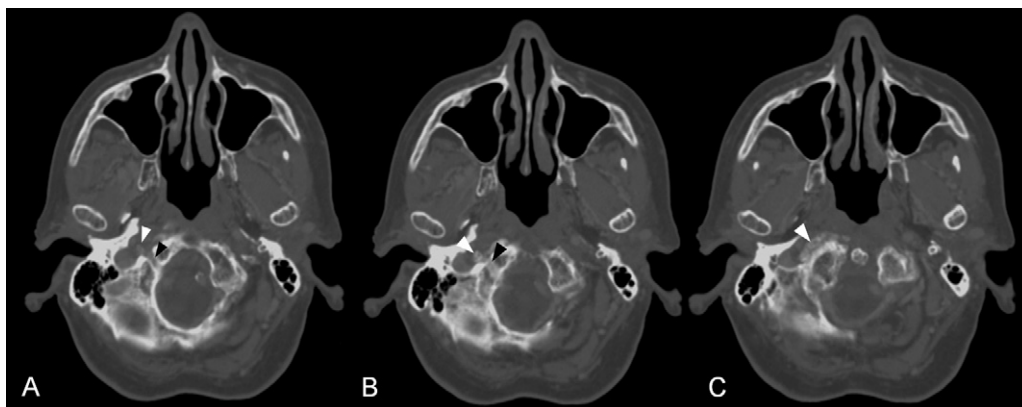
Basicranial CT, axial slices. (A) Black arrow: hypoglossal canal. White arrow: osteophyte. (B) Slightly lower slice, showing the osteophyte (white arrow) in the lower hypoglossal canal (black arrow). (C) Slice through hypoglossal canal. Note osteophyte protrusion (white arrow) into jugular foramen.
